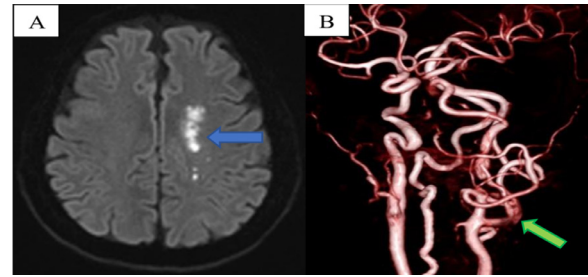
First cerebral magnetic resonance imaging results. (A) Hyperintense lesions were observed in the left hemisphere (blue arrow). (B) Severe ipsilateral internal carotid artery stenosis was identified (green arrow).
